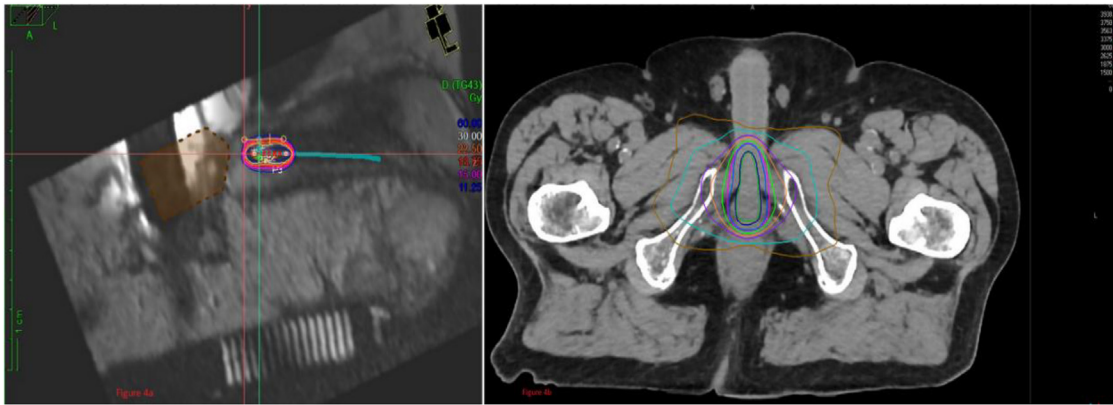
(a) Magnetic resonance imaging (MRI) scan of the pelvis showing brachytherapy dose distribution to the urethral stump (case 5). (b) Planning computed tomography (CT) scan showing the external beam brachytherapy dose distribution to the target volumes (urethral stump and site of anastomosis).
